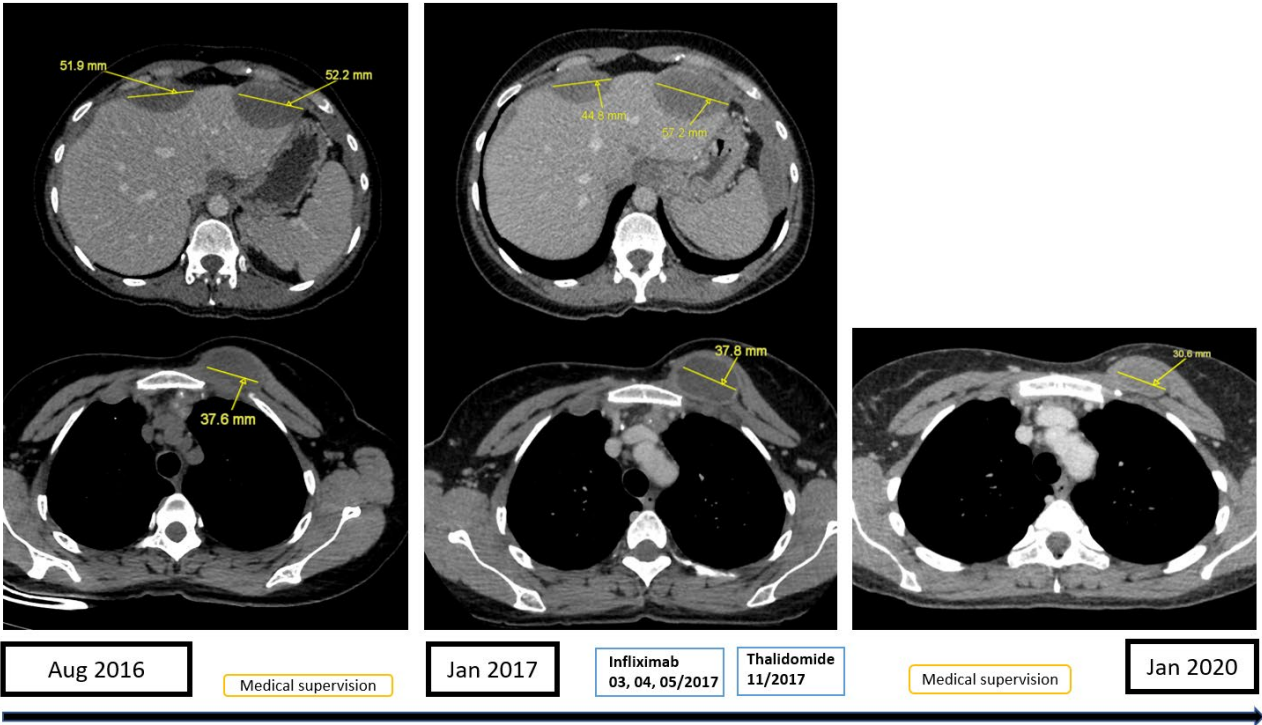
Case report #3: Chest and abdominal contrast-enhanced, axial CT scan. A five-year follow-up of intra-abdominal and presternal collections.
